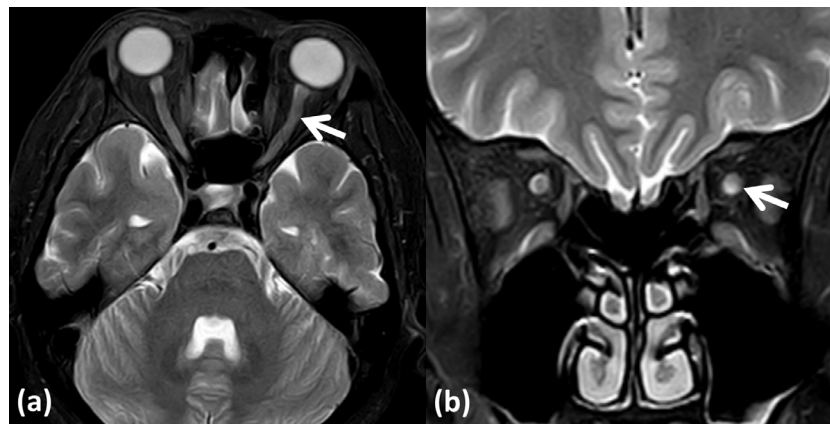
MRI images of the optic nerve on admission. (a) Transverse position. The left optic nerve is swollen and tortuous, and the path is fuzzy (arrow). (b) Coronal position. The fibers and sheath of the left optic nerve are swollen and blurred (arrow).
